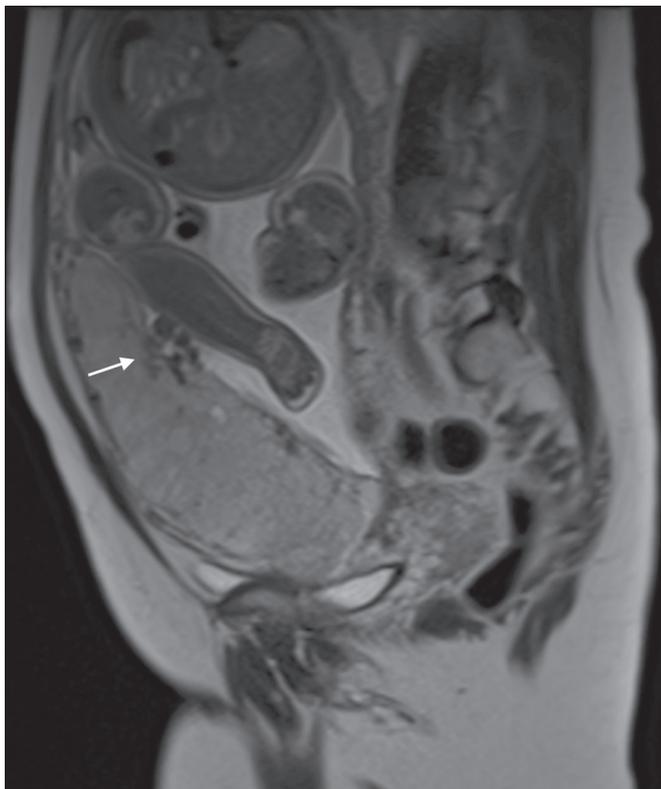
A 39-year-old patient with no signs of placenta accreta. Axial T2-weighted HASTE sequence showing normal intraplacental flow voids near the umbilical cord insertion site (arrow).
